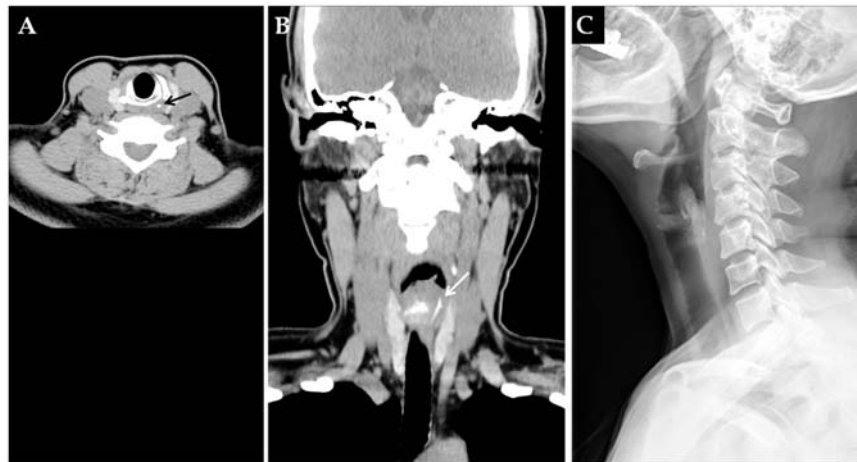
A 50-year-old woman with throat pain. Axial (A) and coronal (B) CT scans demonstrate a linear foreign body in the hypopharynx to the upper esophagus (arrow). There is no evidence of radio-opaque foreign body on lateral cervical radiography (C). She took an esophagoscope examination, but there was no visible foreign body.
